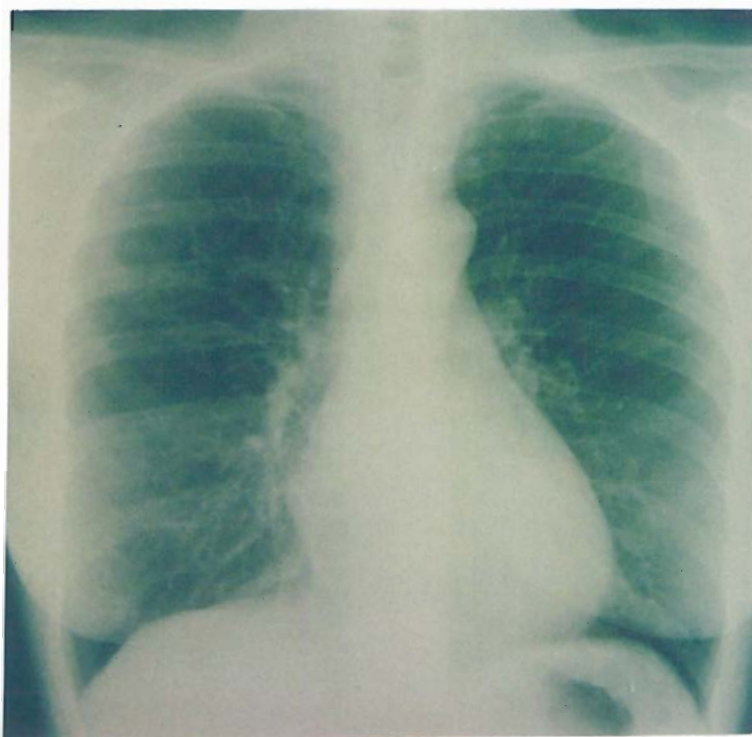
Following 15 days treatment using intravenous cystine and oxidised glutathione followed by radiowaves on each occasion this x-ray 2 months later shows complete resolution of the secondaries. She remains well 3 years later.
